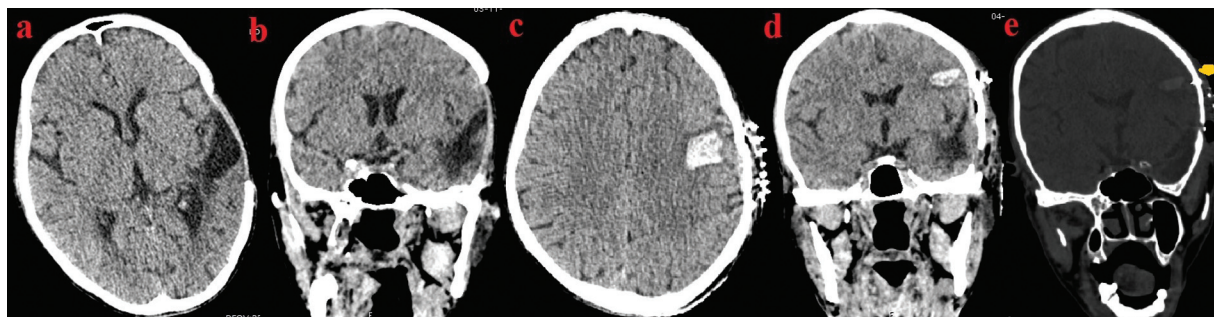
Pre-CP CT scan images (A, B) of a patient operated for left temporal intracerebral hemorrhage showing gliosis at the site of surgery; post CP CT images (C, D) showing an intraparenchymal hemorrhage below the replaced flap but away from the gliotic region and (E) coronal bone windows showing a screw used for fixation of the bone (orange arrow) penetrating the full thickness and causing brain injury.
